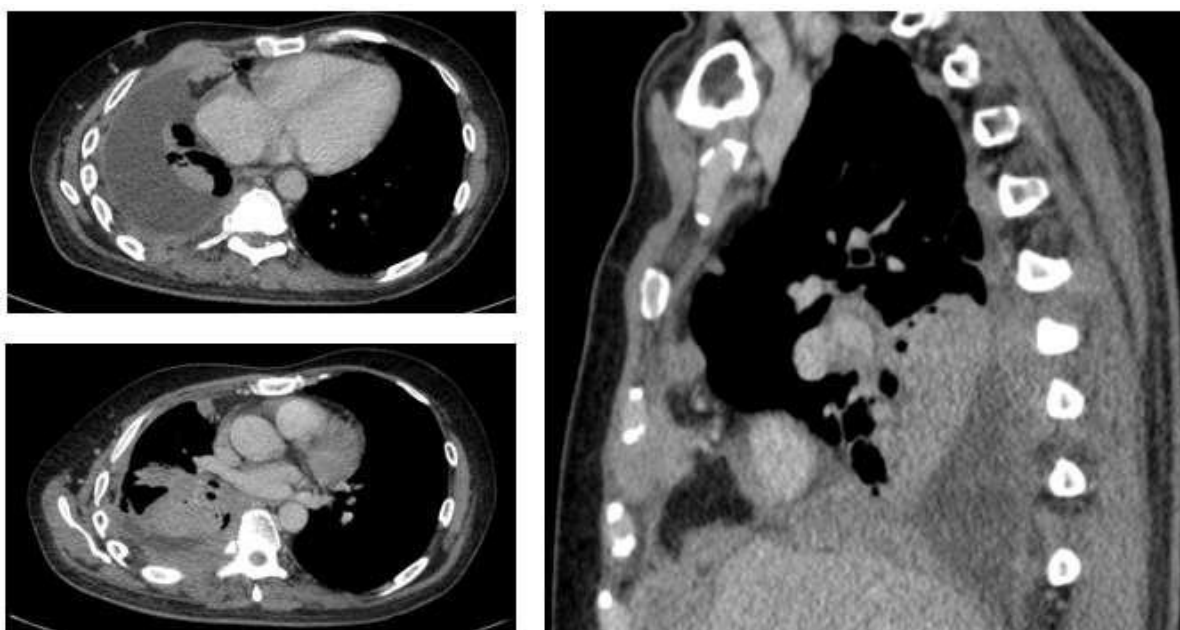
Contrast-enhanced CT in axial and sagittal views demonstrates an irregular soft-tissue mass along the right anterior chest wall at the level of the 3rd–4th intercostal spaces (4.3 × 2.9 × 3.0 cm), infiltrating the intercostal muscles and pericardial fat, accompanied by multiple enlarged pericardial lymph nodes (0.7–1.2 cm)
